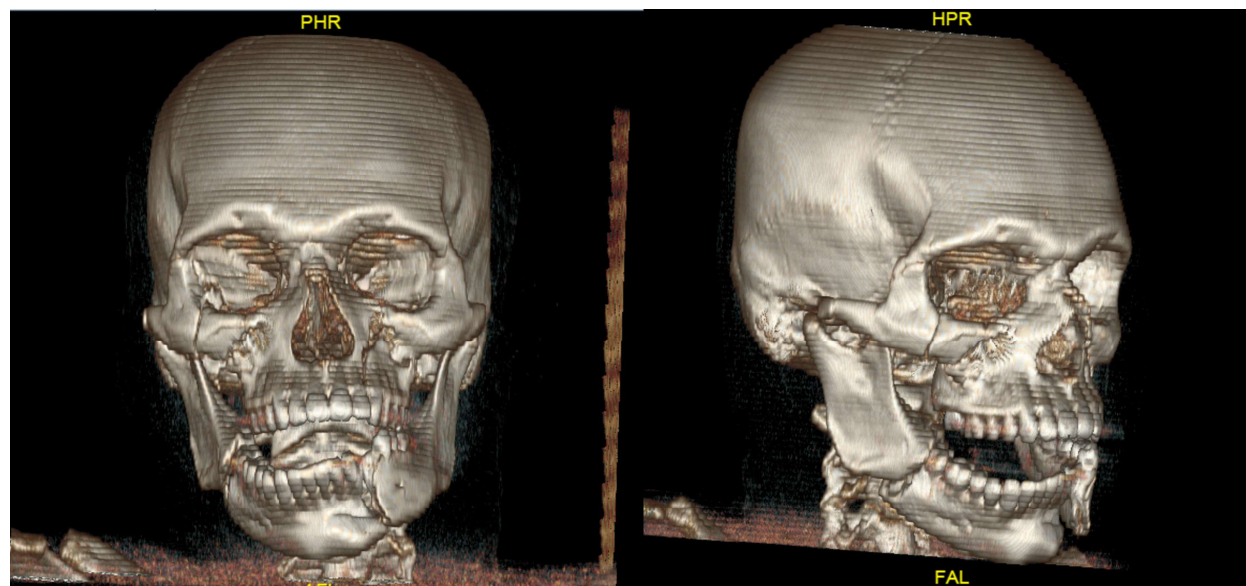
3D CT reconstruction of face (coronal and right oblique view) showing panfacial fractures
